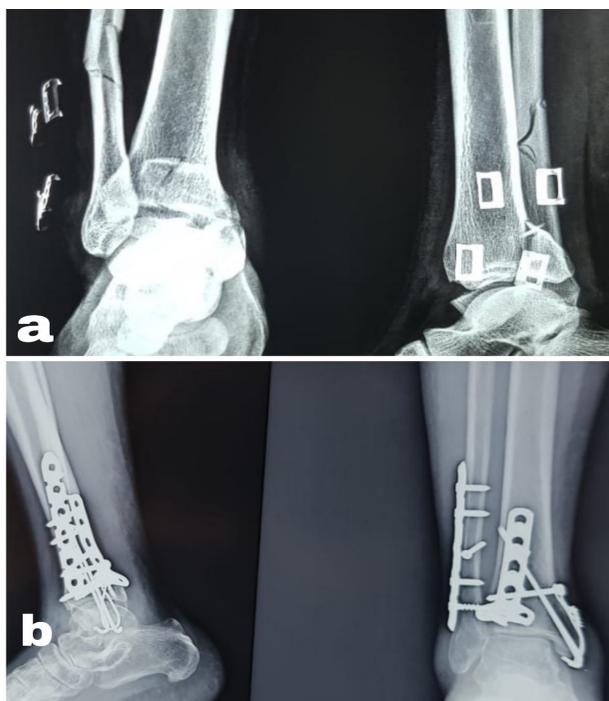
(a): Pre-op x-ray of 46 year old lady with trimalleolar fracture. (b): Two year post-op x-ray of the same lady.
